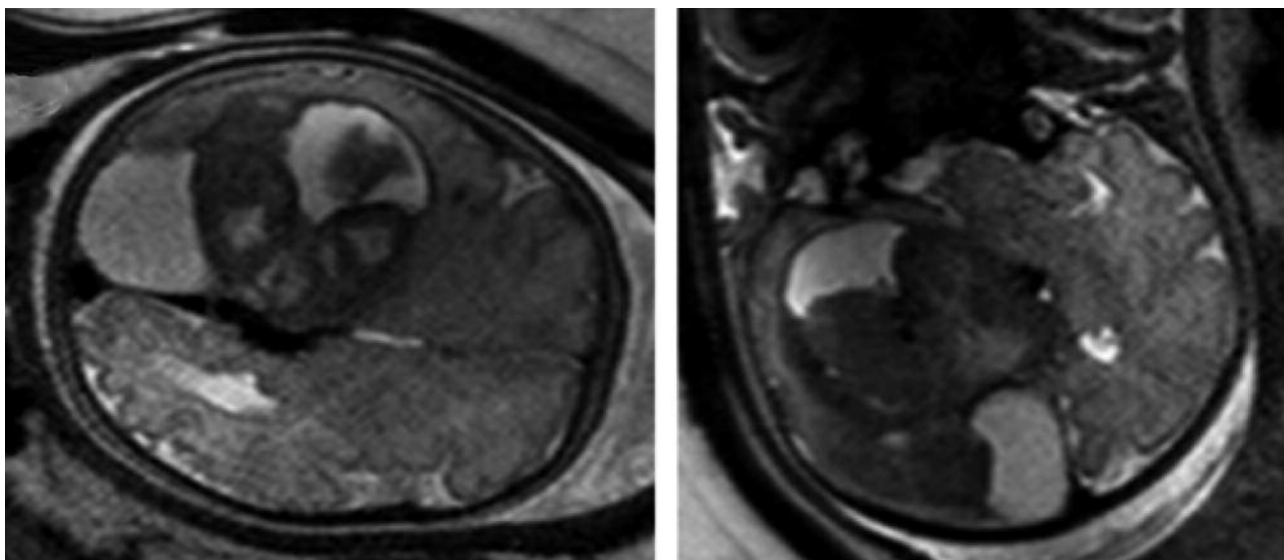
MRI axial (left) and coronal (right) view of a voluminous mixed solid-cystic lesion in the left cerebrum. Note the shift of the midline to the contralateral side. Postoperative biopsy revealed a glioblastoma.
